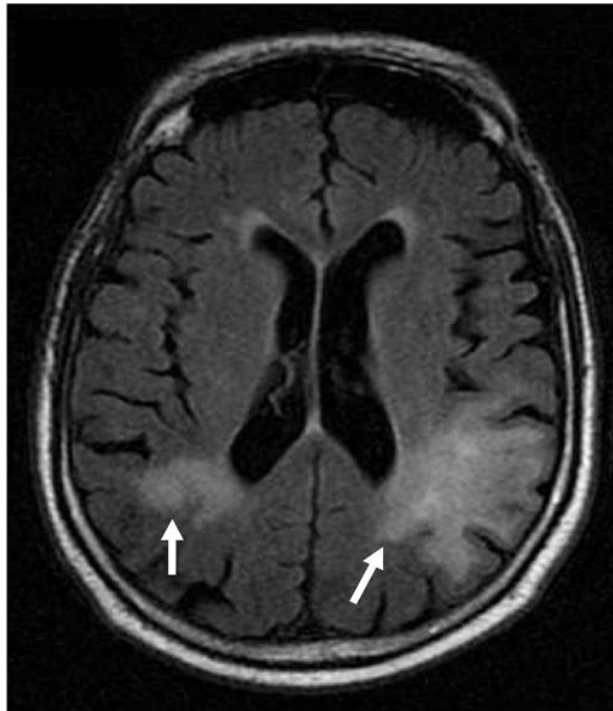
PML Pathogenesis. MRI of PML plaques (indicated by arrows) within the brain of a 70-year old patient. [15] (Figure adapted with permissions form Journal of NeuroVirology).
